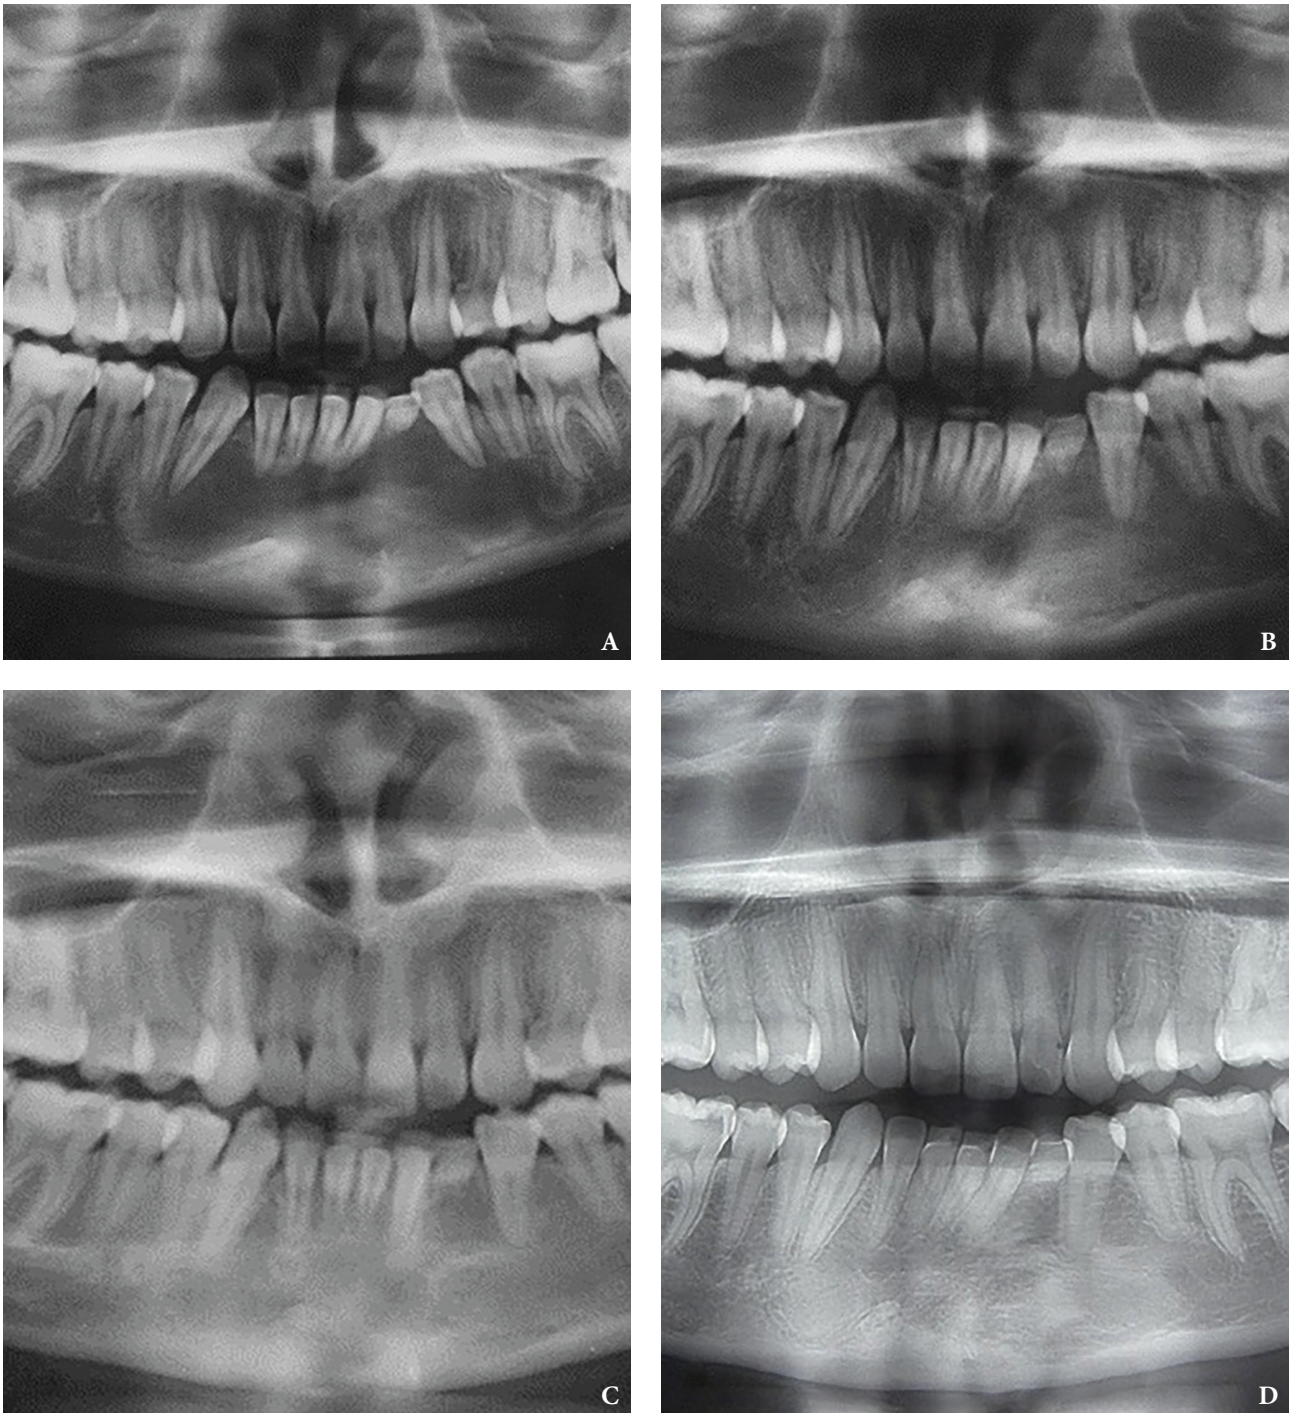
Case 4: Cropped panoramic radiography. A: Immediate post-op. B: 1 year post-op. C: 2 years post-op. D: 3 years post-op.
